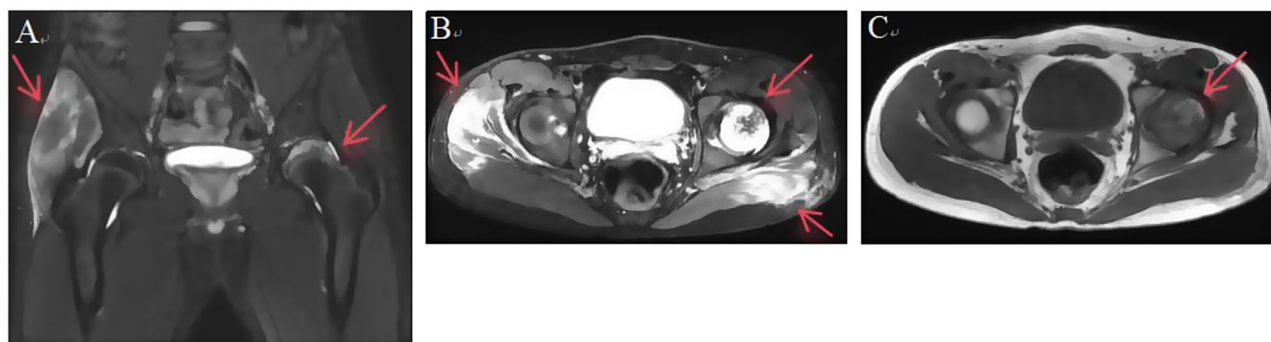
(A) On the magnetic resonance imaging (MRI) coronal T2-weighted (T2WI) compression fat image of the hip, patchy high signals of the left femoral head epiphysis and the right gluteus maximus and minimus muscles are observed. (B) On the axial T2WI compression fat image of the hip, patchy high signals of the left femoral epiphysis, the right gluteus medius, the left gluteus maximus, and the adjacent subcutaneous soft tissues are noted. (C) On the axial T1WI image of the hip, a low signal from the left femoral head epiphysis was detected
